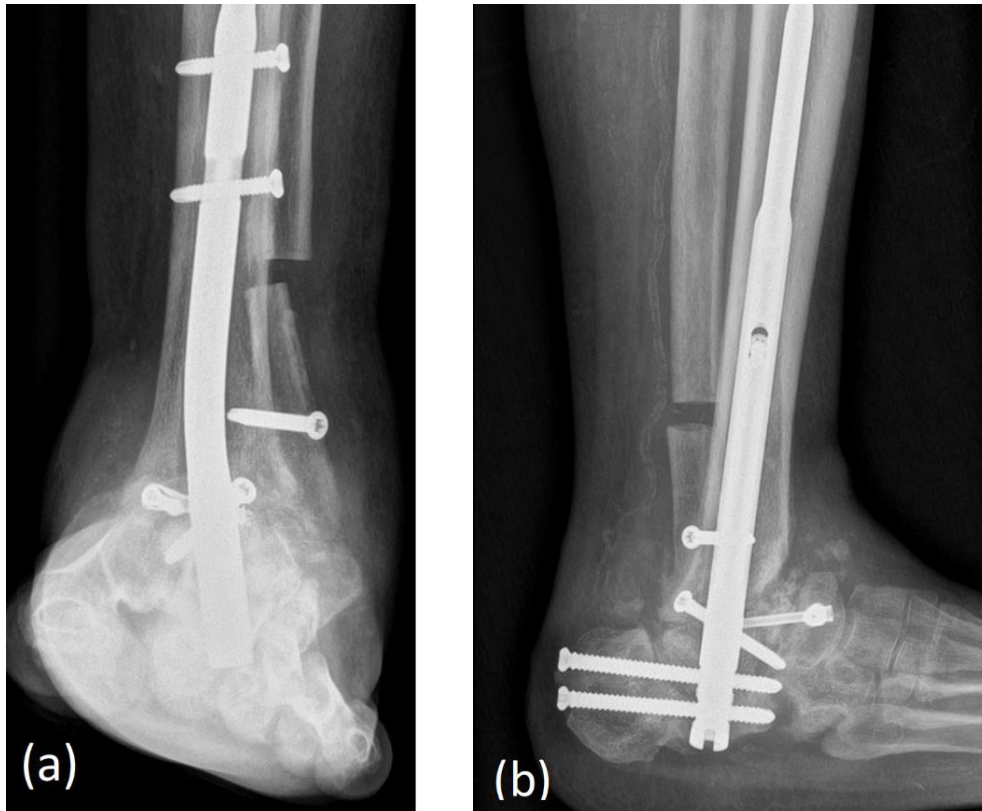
(a) AP view and (b) Lateral view of immediate postoperative radiographs of left ankle show hindfoot arthrodesis nail in-situ
